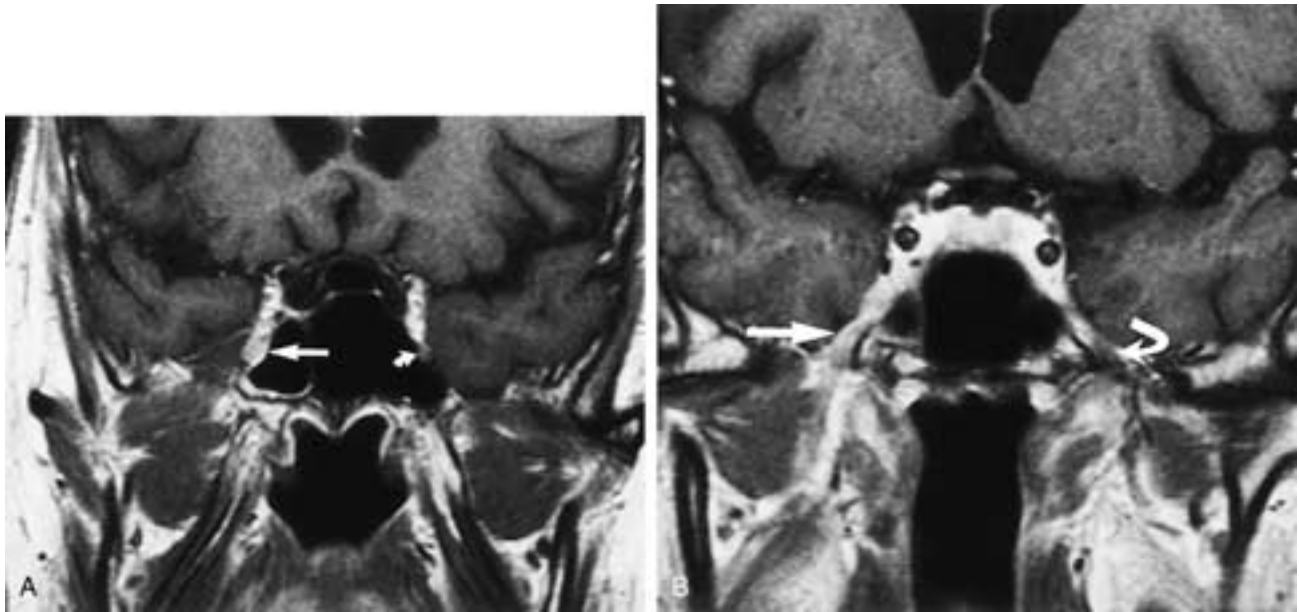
A, Coronal-enhanced T1-weighted MR image shows enlargement and enhancement of the second division of the trigeminal nerve (*straight arrow*) caused by perineural spread of squamous cell carcinoma. Note the normal appearance of V2 on the opposite side (*curved arrow*). B, Postgadolinium coronal T1-weighted MR image shows perineural spread of tumor along the third division of the trigeminal nerve (*straight arrow*). Note the normal appearance of V3 on the opposite side (*curved arrow*).
